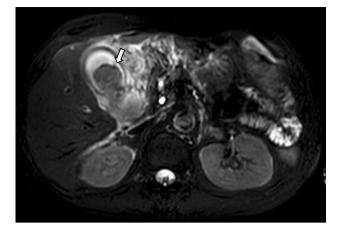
Preoperative MRI imaging of the gall bladder. A mass mimicking a gall stone (open arrow) was present in the gall bladder on
